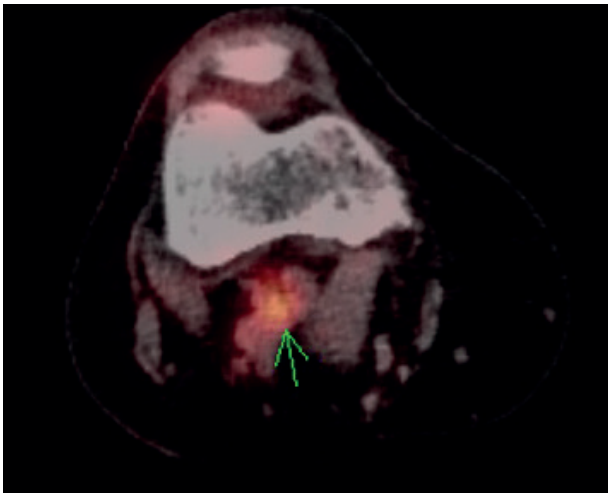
Axial fused positron emission tomography computed tomography scan showing the popliteal fossa lymph node with high standardised uptake value.
